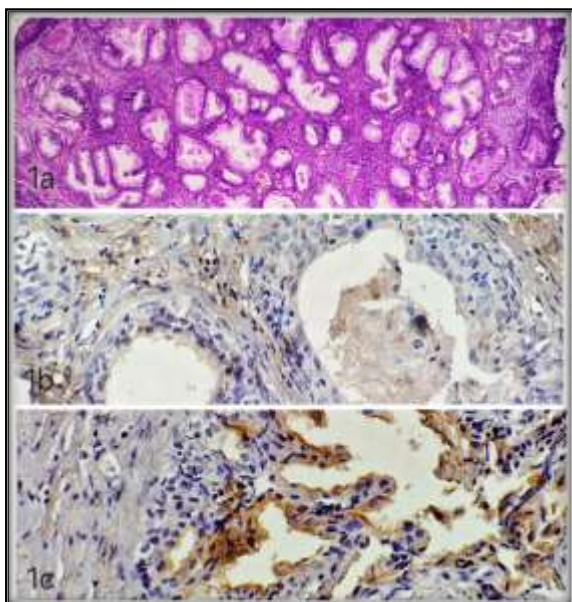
Benign prostatic hyperplasia (BPH), 1b: Negative Glyoxalase-1 expression in BPH, 1c: Weak membranous PSMA expression in BPH
